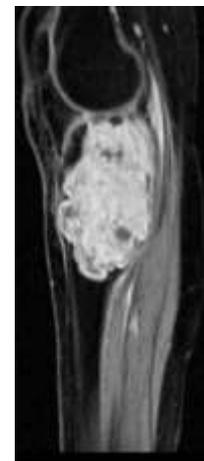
Input MRI image
